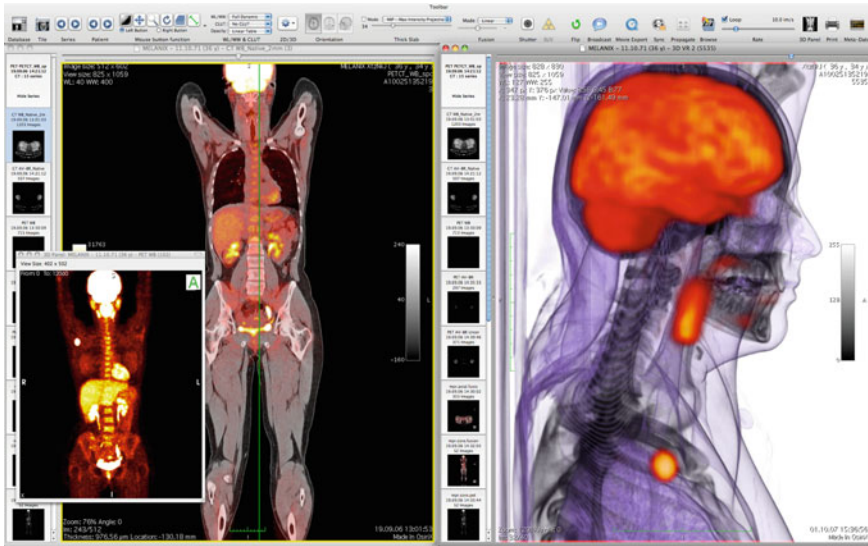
Pet-CT (hybrid scanner) and 3D viewers in OsiriX
